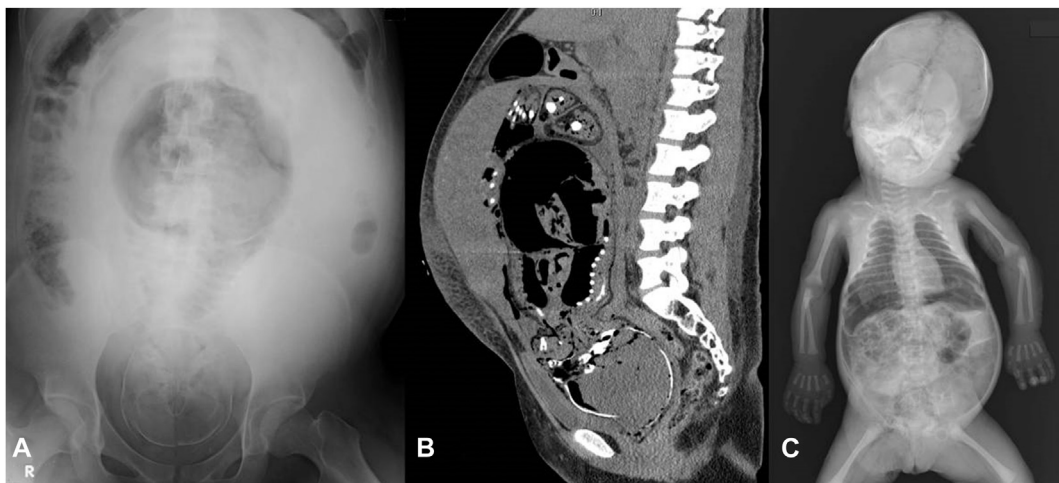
(A) An anteroposterior radiograph showing a mature single fetus with cephalic presentation. A uterine wall shadow and a volume of gas in the uterine cavity are observed. The Spalding's sign is positive. (B) A sagittal view of the noncontrast computed tomography scan of the patient's pelvis and abdomen. There are abundant gas bubbles in the subdural space of the fetus' skull as well as in the thorax, extremely dilated gastrointestinal tract, mesenteric and portal veins, and soft tissues. The amniotic cavity is occupied by large amounts of gas and a small amount of fluid. The placenta is attached to the anterior wall of the uterus, and the uterine muscle tissues do not show emphysematous changes. Although the maternal gastrointestinal tract is paralytic, there is no finding indicating active infiltration of the maternal peritoneal cavity such as intraperitoneal free air. (C) An anteroposterior radiograph of the stillborn infant immediately postdelivery. A volume of gas is observed in the thoracic cavity, abdominal cavity, and bowel, and there is subcutaneous gas throughout the extremities and the trunk.
